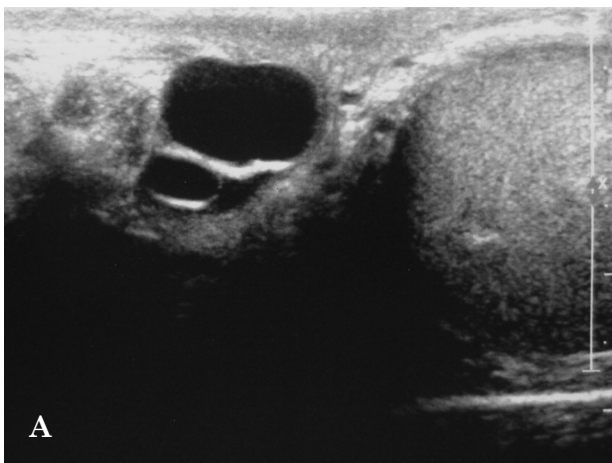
A – transverse sonogram of left testis in 14-year-old patient shows two cysts of the head of epididymis; B – intraoperative view of two pedicled cystic appendages of epididymis in the same patient
